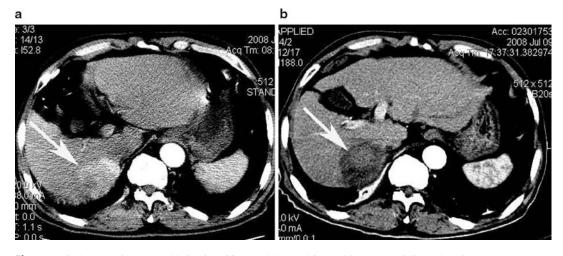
915-MHz microwave ablation in a 66-year-old man with a large HCC in the right hepatic lobe. (a) Contrast-enhanced CT before MWA shows
